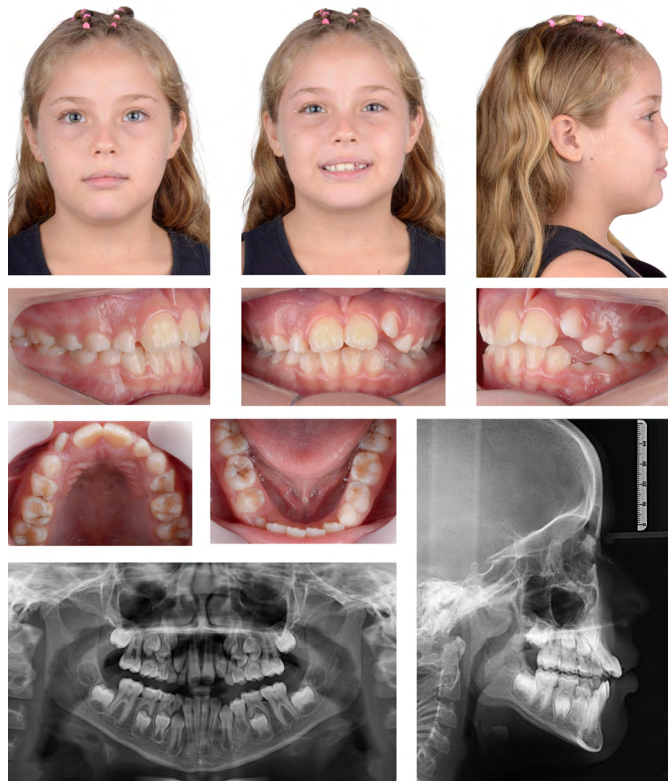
Pre-treatment records of Patient 1, including intraoral and extraoral photographs, panoramic radiograph, and lateral cephalometric radiograph.
